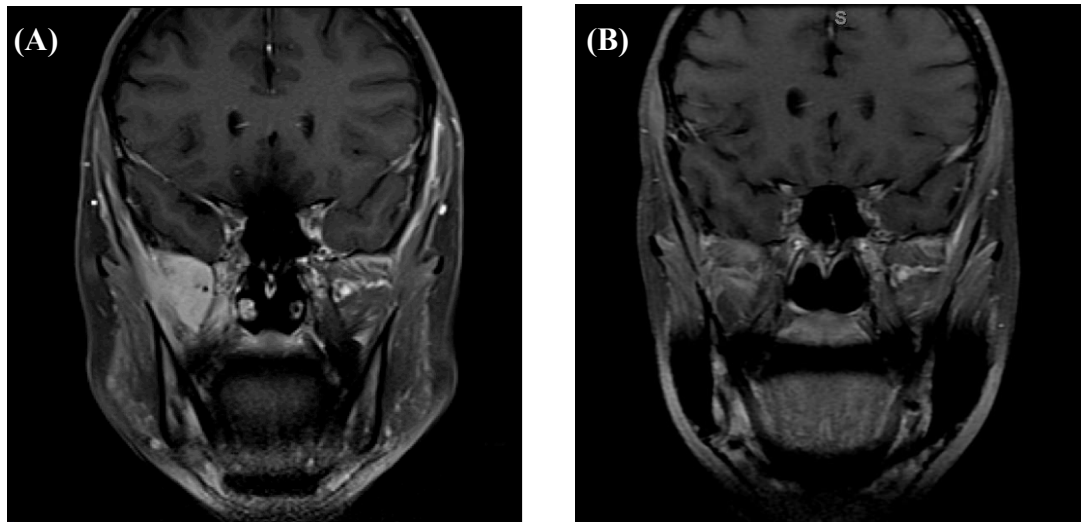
T1 MRI pre and post treatment. (A), Pre-treatment contrasted coronal T1 MRI showing diffuse, enhancing, infiltrative mass involving the infratemporal fossa, oropharynx, and soft palate, extending into the foramen ovale with displacement of the trigeminal ganglion, in addition to questionable involvement of the right facial nerve and right vidian canal. (B), Contrast-enhanced coronal T1 MRI seven months after completion two cycles of rituximab, demonstrating significantly less enhancement in the infratemporal fossa.
